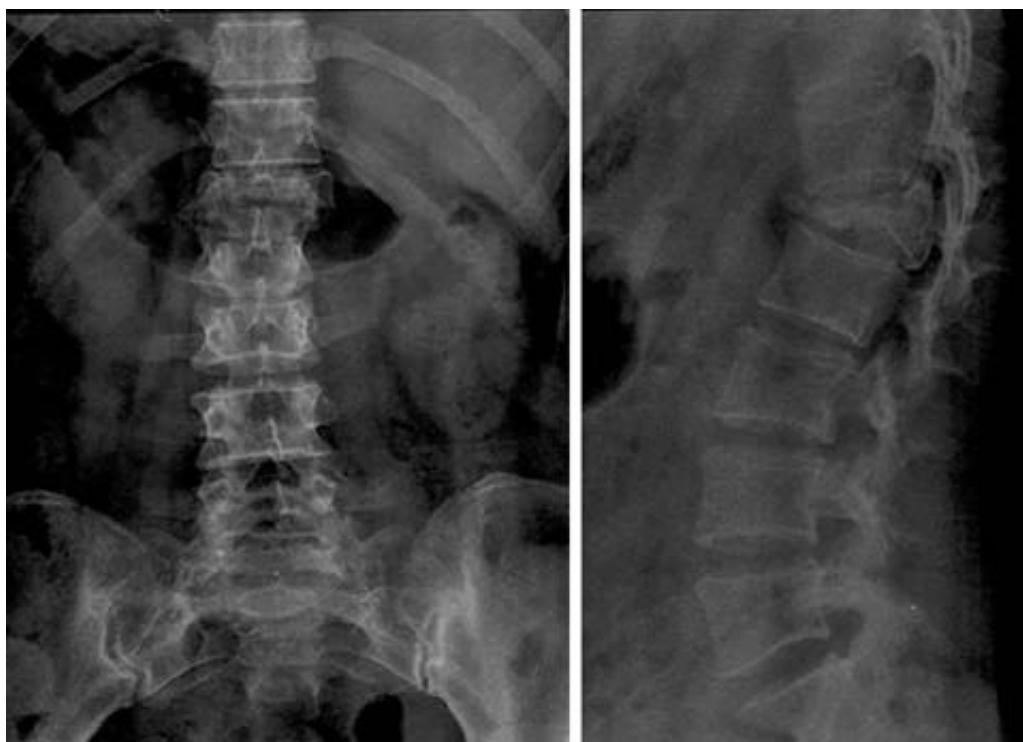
In simple radiographs, it shows widening of interpedicular distance, collapse of anterior and middle column and interspinous widening.
